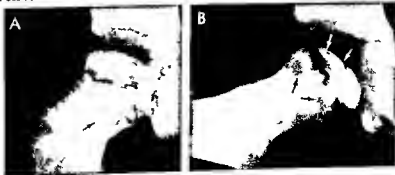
586 —Coxa plana in the late stage of flattening and fibrous replacement with double metaphyseal lesions. This boy 5 years of age began to limp only 24 hours before this film was made. Although the radiographic changes suggest that the disease has been present in the right femur for many months. The right epiphyseal ossification center is flattened and irregularly sclerotic. The cartilage space of the joint is increased. Two large radiolucent patches extend caudad directly off the cartilage plate deeply into the metaphysis. The femoral neck is widened and the right femur dislocated laterad in its acetabulum (Waldenström sign). The scapular roof is roughened.
